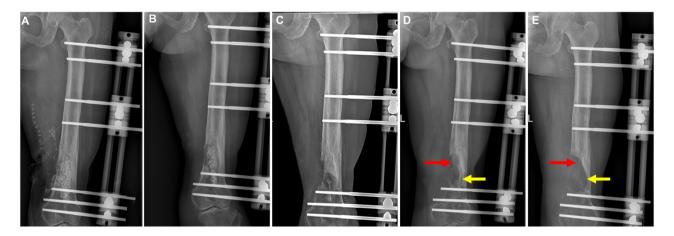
Postoperative follow-ups of X-ray images. (A) Immediate postoperative radiography showed implantation of the rail fixator with calcium sulfate containing antibiotics. (B and C) X-ray images at (B) 1 and (C) 4 months after the surgery revealed gradual biodegradation of the calcium sulfate beads with new bone formation. (D and E) X-ray images of the postoperative (D) 7 and (E) 10 months indicated abnormal osteolysis signals.
